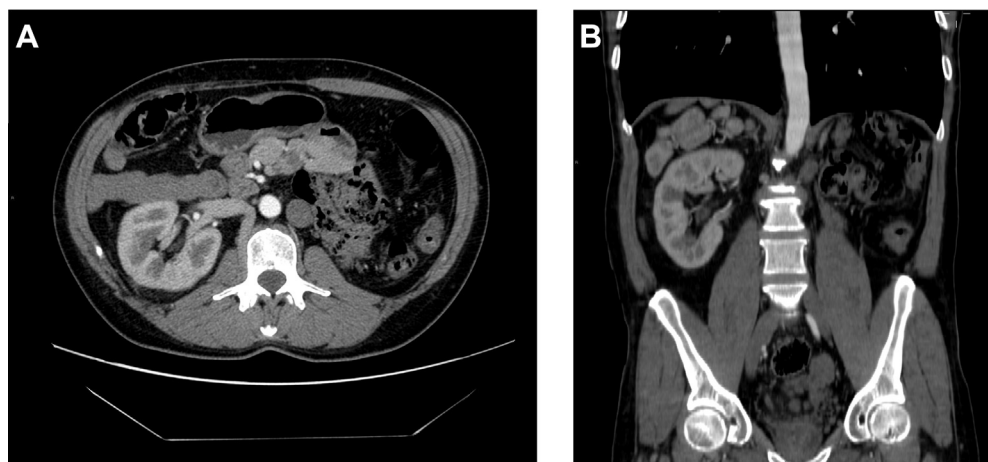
Contrast-enhanced axial CT of the abdomen (A) with coronal (B) reconstructions shows a left kidney agenesis.
